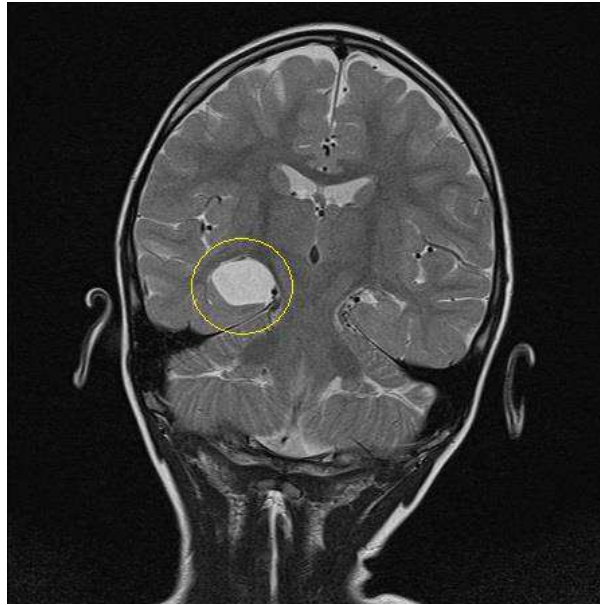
MRI T2 sequence. Coronal plane. Large cyst in the right temporal area. Might be an epileptogenic source.
